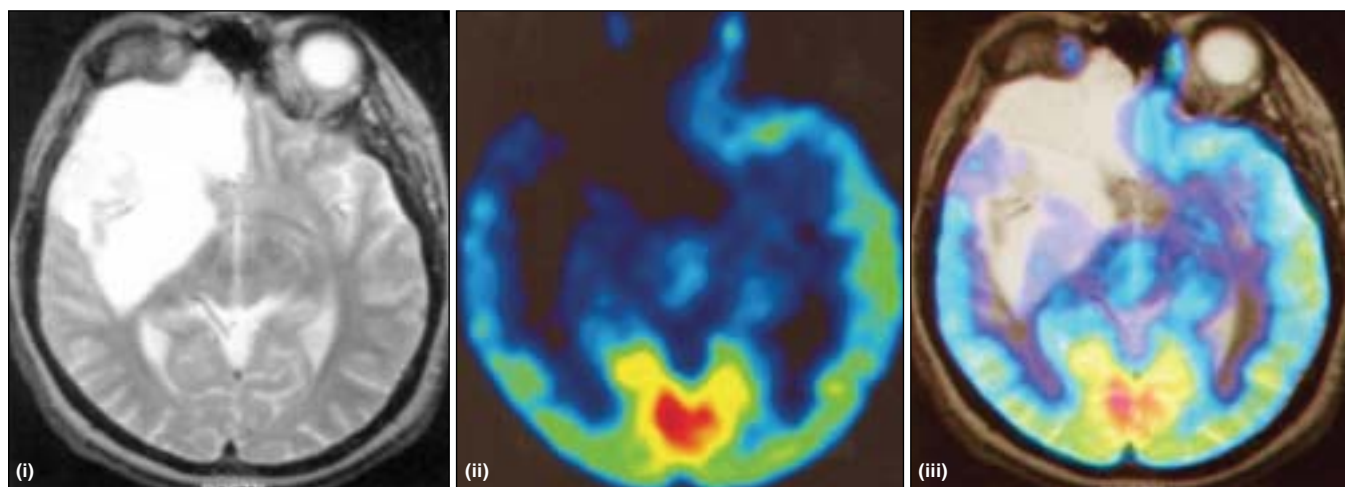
Neuroradiological features in 1994. The corresponding axial slice of MRT (i), ^{18}F FDG-PET (ii) and the merged co-registered scans (iii) made after a diagnosis of the recurrent tumor. The ^{18}F FDG uptake of the whole tumor is less than the normal brain tissue's
